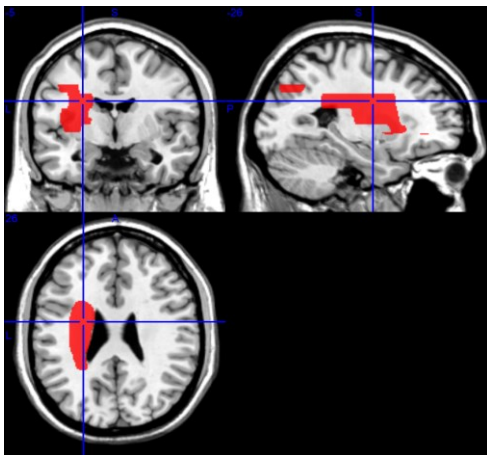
Superimposed CT scan abnormalities for 9 cases of small lesions and severe apraxia. The lower cuts have lower numbers.
